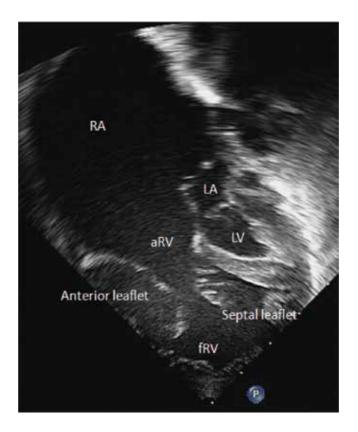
Apical 4 chamber view of Ebstein's anomaly with severe enlargement of the right atrium and atrialized portion of the right ventricle. There is apical displacement of the tricuspid valve with tethering of the septal leaflet leading to poor coaptation and tricuspid valve regurgitation. RA: Right atrium. LA: Left atrium. aRV: Atrialized right ventricle. LV: Left ventricle. fRV: Function right ventricle.
